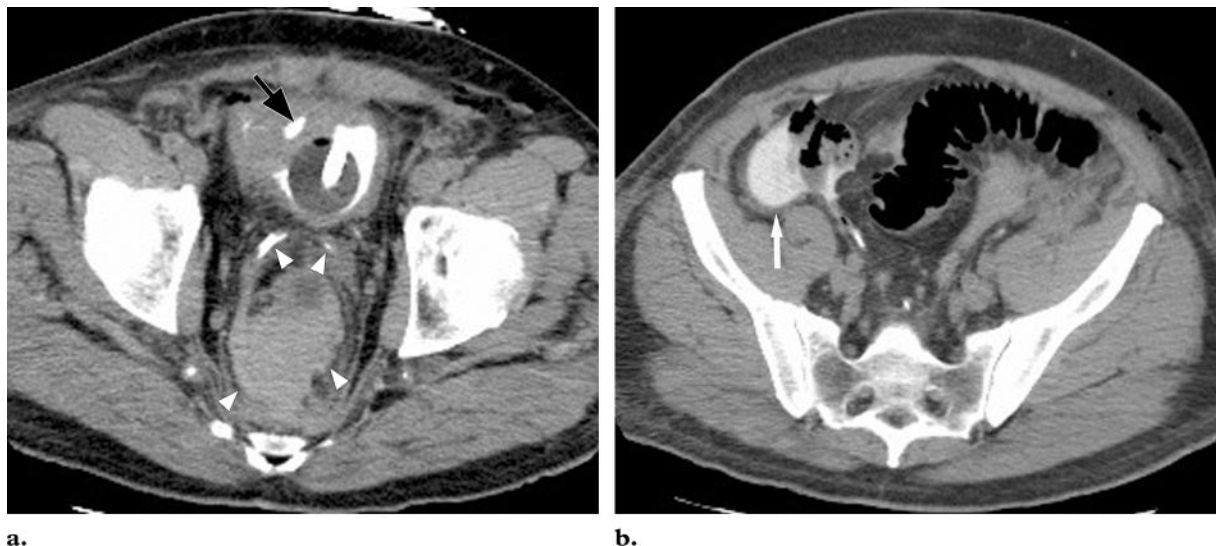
Intraperitoneal bladder injury in a 65-year-old man who had undergone laparoscopic low anterior resection. Continuous high outputs from the surgical drains were seen postoperatively. (a) CT cystogram demonstrates a bladder catheter and contrast material within the urinary bladder. Note the contrast material posterior to the bladder (arrowheads) and the surgical drain traversing the urinary bladder dome (arrow). (b) CT cystogram obtained cephalad to a demonstrates intraperitoneal leakage of contrast material into the right paracolic gutter and adjacent to the cecum (arrow). The surgical drain was removed, and the patient was successfully treated with prolonged bladder catheter drainage alone. Although most intraperitoneal bladder injuries require surgical intervention, many iatrogenic injuries to the bladder are minor and can be managed conservatively.
